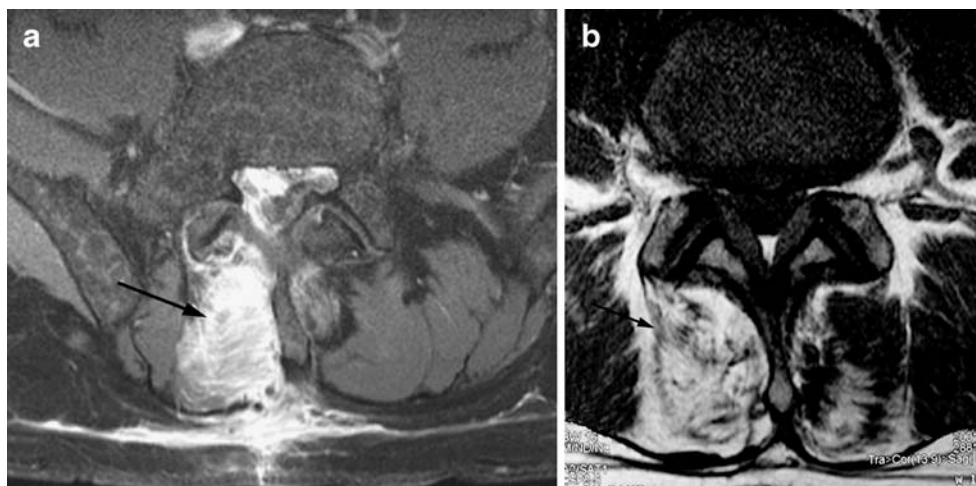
Neurogenic degeneration of the right multifidus muscle in a 61-year-old patient with degenerative spine disorder and chronic low back pain. Presence of isolated multifidus muscle involvement (*arrow*) on gadolinium-enhanced T1-weighted image [time to repeat (TR) 460 ms; time to echo (TE) 25 ms] with shape modification ipsilateral to the patient's pain
